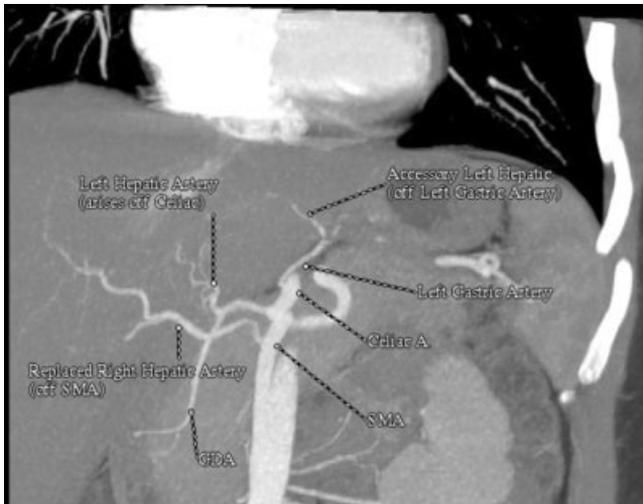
Semiautomated, volume-rendered image obtained following routine CT scanning.
